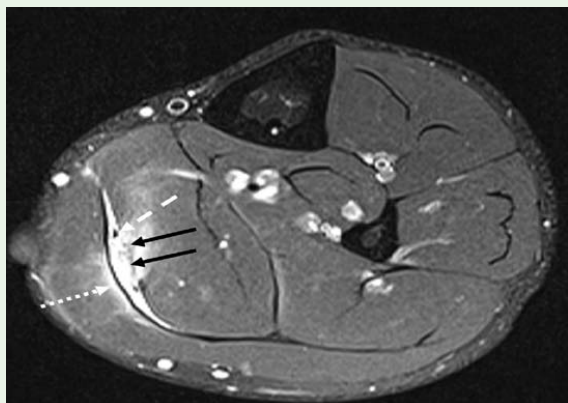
28-year-old elite national level ARF player with history of multiple left calf tears presenting with acute medial soleus and gastrocnemius aponeuroses tears. Axial T2-FS left calf MRI showing focal disruption of the medial soleus aponeurosis with myoaponeurotic tearing (black arrows) lateral to the plantaris tendon (dashed arrow). Low-grade signal changes are present within the Medial Gastrocnemius (MHG) aponeurosis and plantaris tendons compatible with micro-tearing, as well as low grade myoaponeurotic injury of the MHG (dotted arrow).
